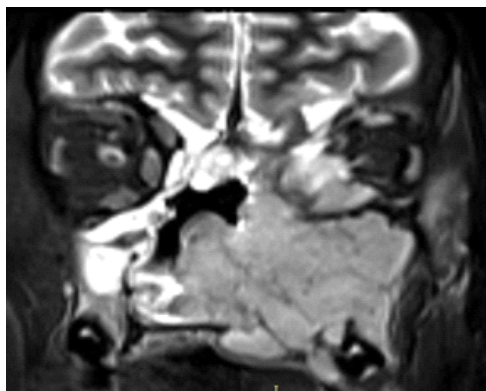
Coronal T2W MRI showing well defined isointense mass in left nasal cavity extending into maxillary sinus and orbit.
